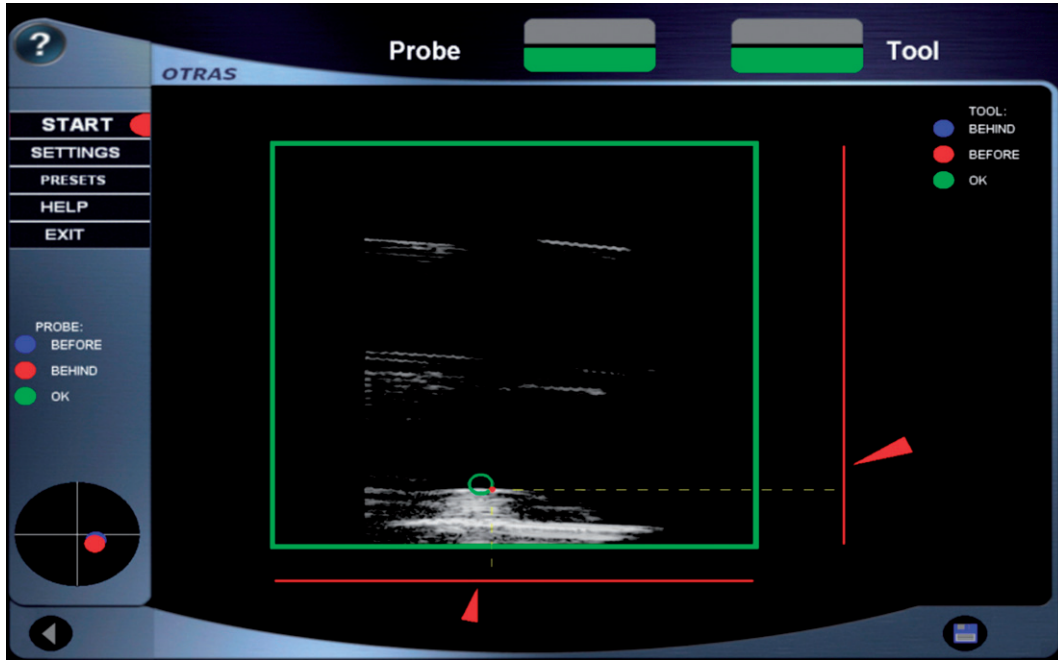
Target structure in the ultrasound image (green circle). The red navigation aids (bars, arrows, point) indicate the distance to the target structure and the proposed insertion channel for the surgical instrument. When the target has been successfully touched, the color of the navigation aids will change to green.
